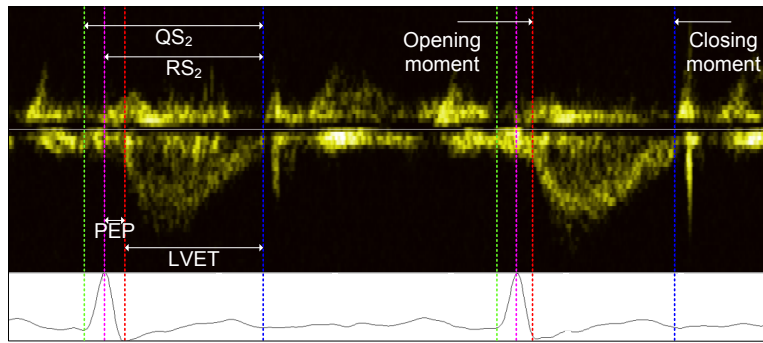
Annotations of aortic valve timings using Doppler mode echocardiography.
